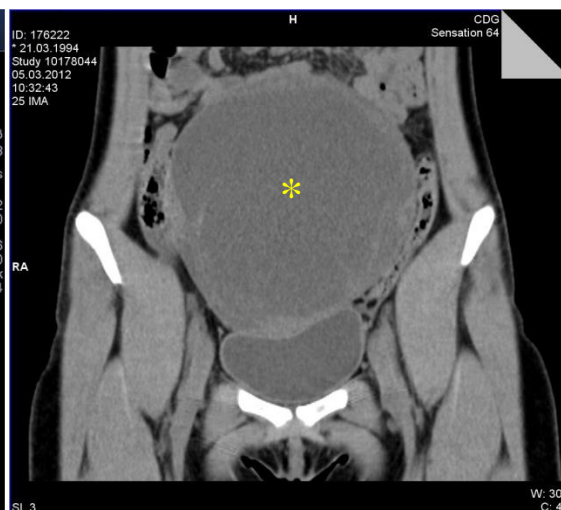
Computed tomography: giant ovarian serous cystadenoma (158x1381x14 mm) of the right ovary (*)
